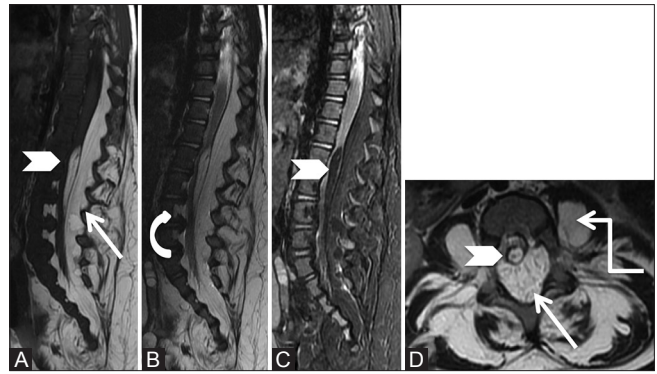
(A-D): Benign lesions: Lipomatosis: Sagittal T1-weighted (A), T2-weighted (B), T2 fat saturated (C), and axial T2-weighted (D) images of lumbar spine in a 11-month-old female showing excessive fat in the posterior epidural space (arrow), which also extends laterally and causes scalloping of vertebral bodies (curved arrow). It is associated with filum terminale lipoma (arrowhead). Also note lipomatous tissue in both paraspinal and psoas muscles (elbow arrow)
